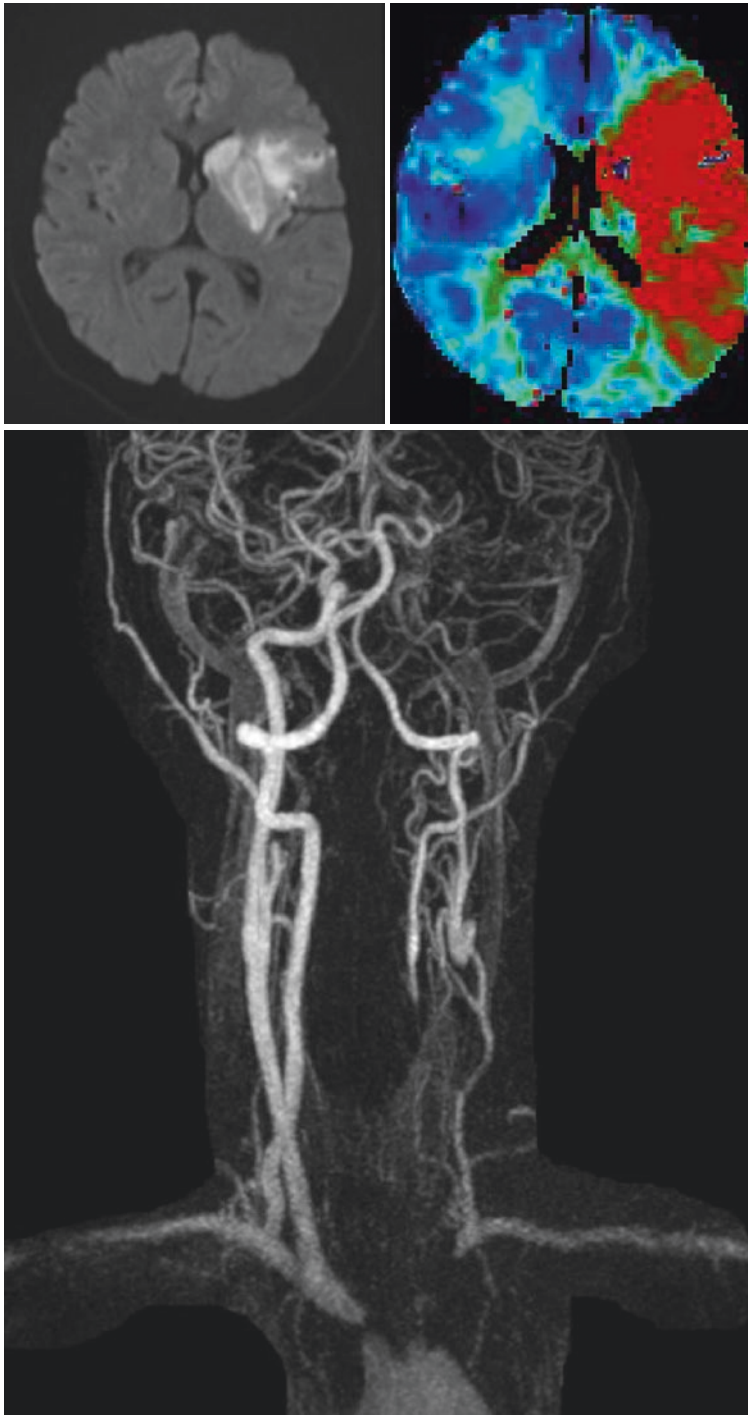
A 39-year-old woman without vascular risk factors developed global aphasia and right hemiparesis. DWI showed left middle cerebral artery (MCA) territory infarction (upper left). Perfusion MRI showed decreased perfusion in the whole left MCA territory (upper right).
